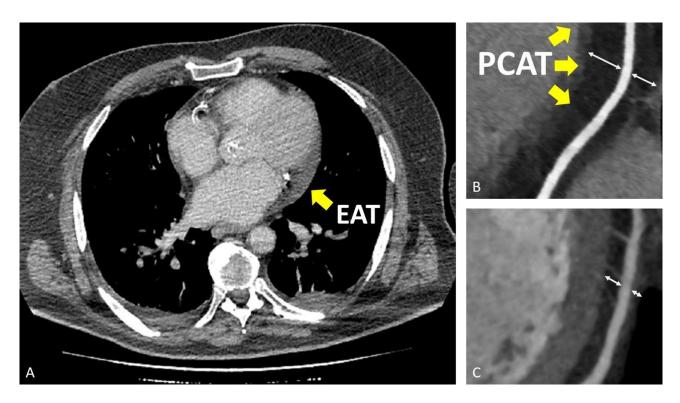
Thoracic Computed Tomography (CT) showing evidence of epicardial adipose tissue (A); detailed coronary CT showing evidence of pericoronary adipose tissue (B); detailed coronary CT at follow-up showing reduction of pericoronary adipose tissue thickness (C).
